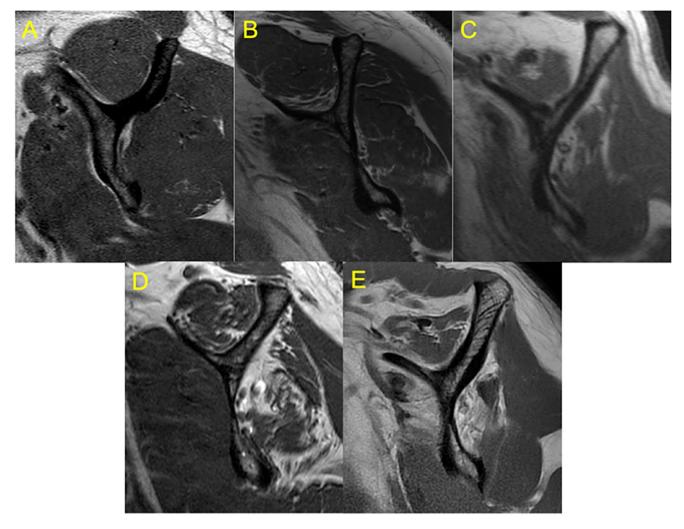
Fuchs modification of the Goutallier classification using sagittal MRI. (A) Grade 0, (B) Grade 1, (C) Grade 2, (D) Grade 3, and (E) Grade 4 fatty infiltration of the infraspinatus muscle
